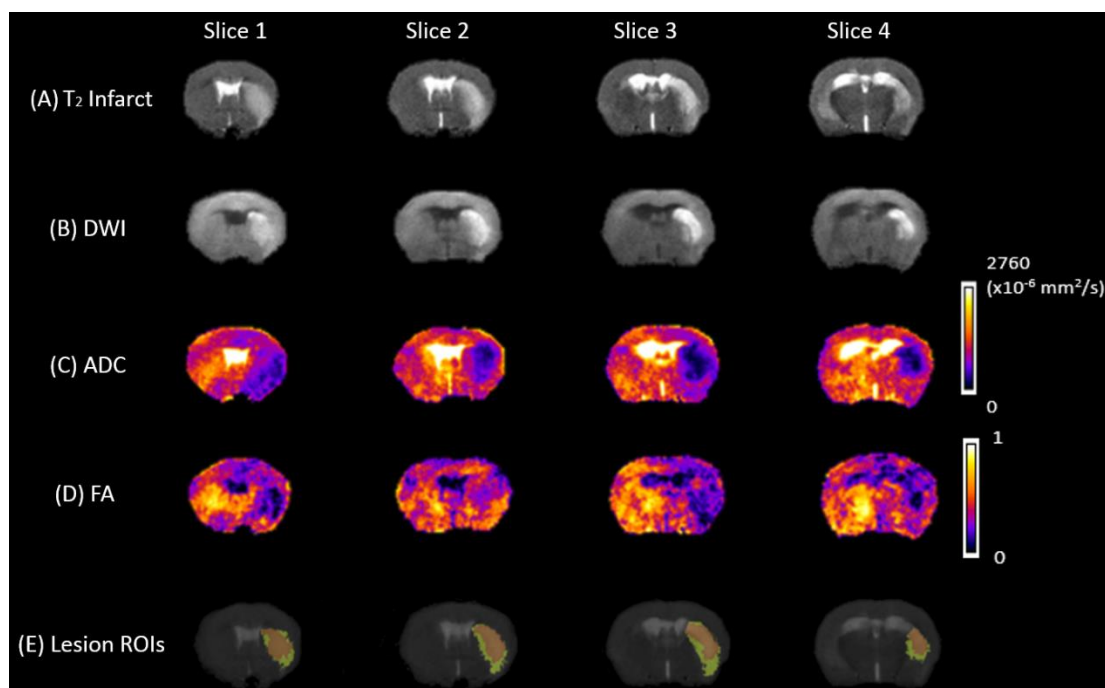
Sample MRI images acquired at 48-hour post-MCAO. T2w images were used to assess lesion volume (A). DWI allowed identification of the lesion core (B). ADC and FA maps were used to assess severity of tissue damage within the lesion (C, D). Combination of T2w and DWI allowed identification of core (red) and penumbra (green) regions of interest (E).
